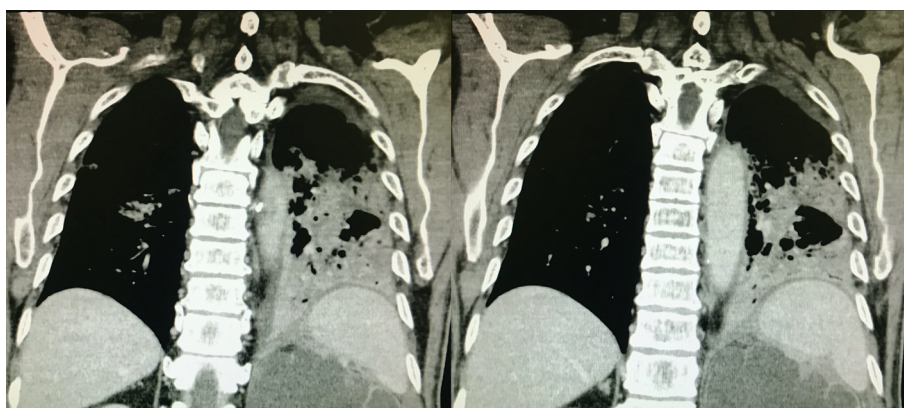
CT after left lower lobe pneumonia with no fistula tract and no intra-renal gas.
